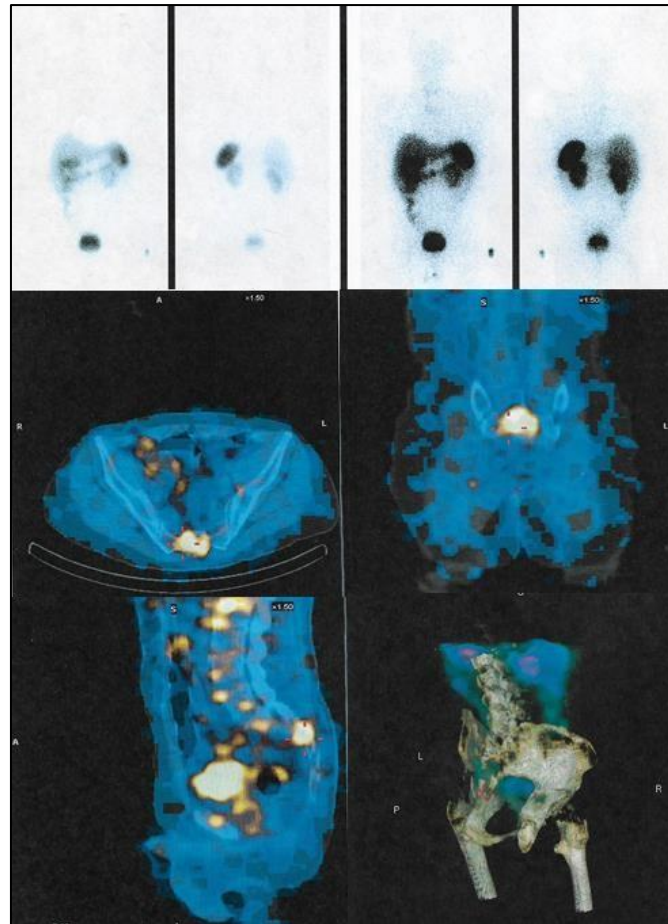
SPECT-CT octreotide Indium 110 images.
